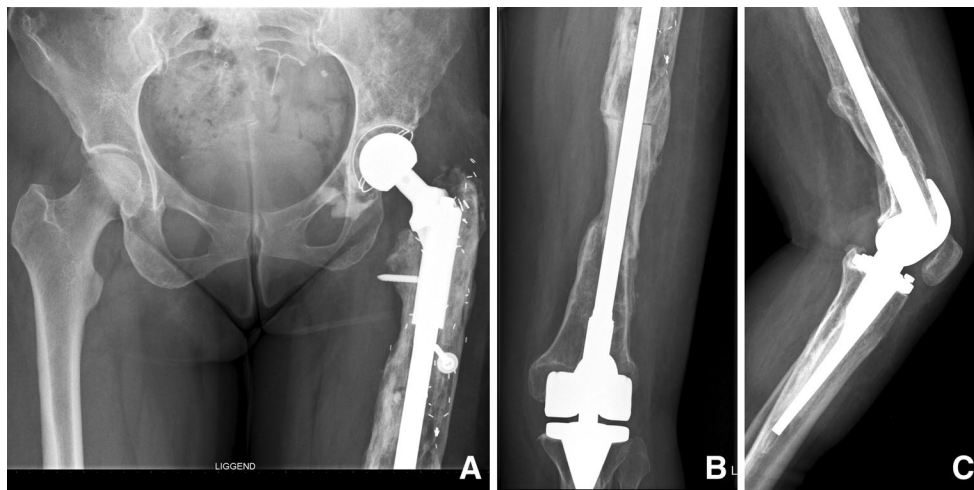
An example of the push-through prosthesis taken one year post-operatively. a Anterior-posterior radiograph of the pelvis, showing the proximal PTF and Exeter cup. The push-through stem provides stability after several failed osteosynthesis attempts and a vascularised fibula
